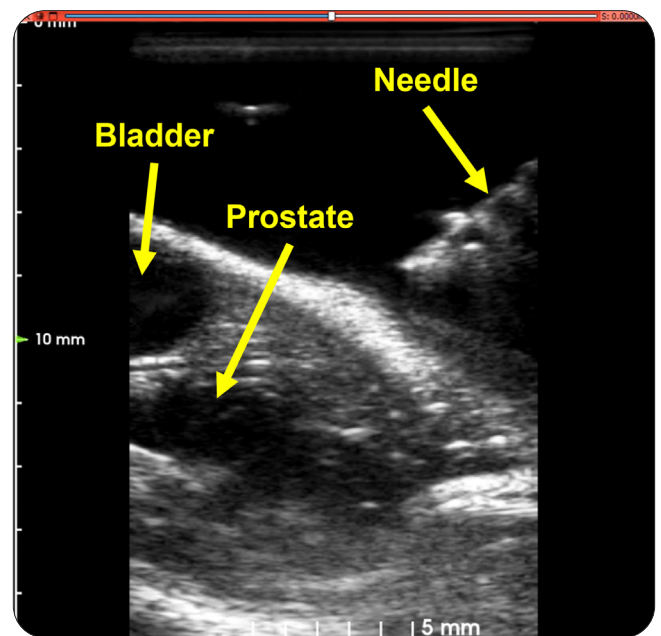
View of the prostate and bladder in the ultrasound livestream.
